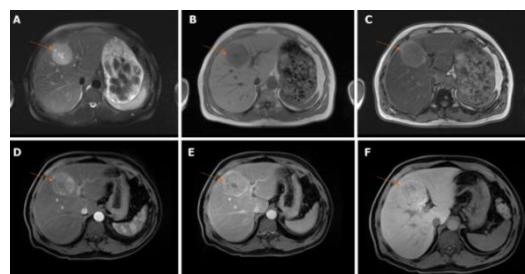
Enhancement of HCC at contrast-enhanced MRI
